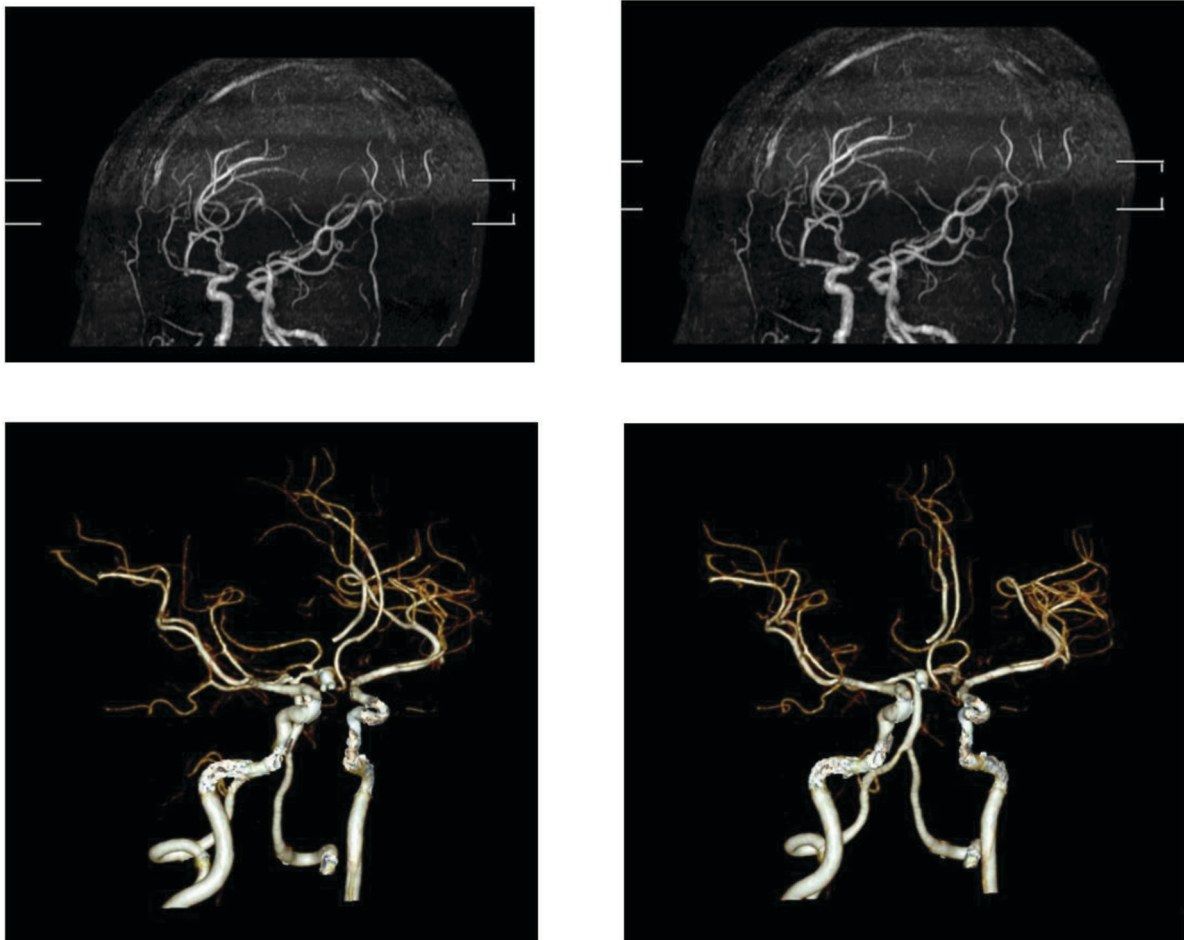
MRI-MRA Brain (03/04/2023) vs CTA Brain (05/04/2023)
